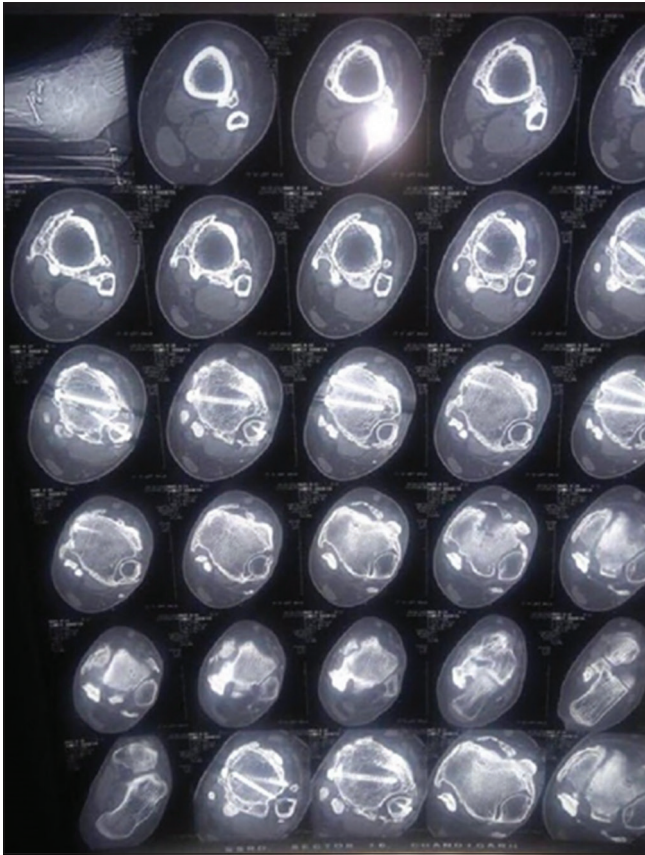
Pre-operative CT scan of left ankle with an axial view: There is evidence of new bone formation in the posteromedial aspect of the tibia and also adjacent to the anterolateral aspect of the metaphysal portion of the tibia
